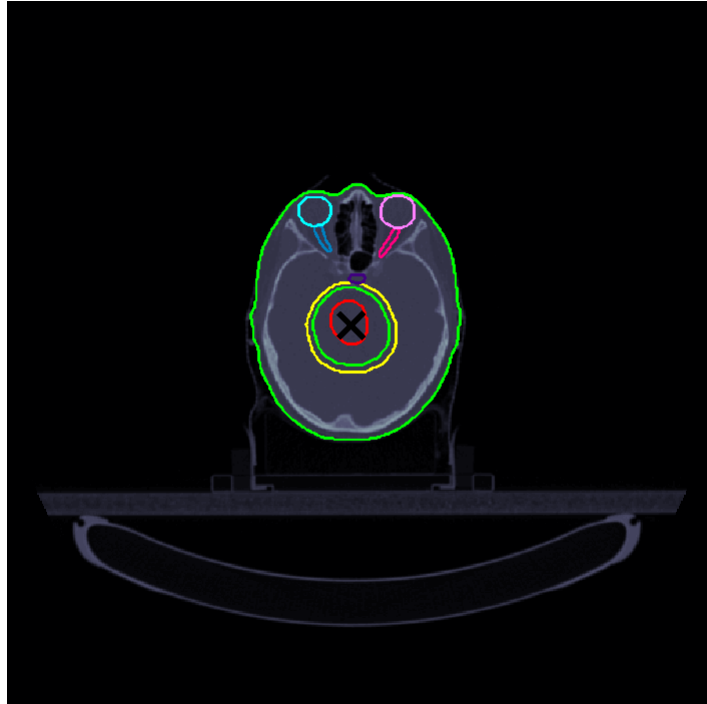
Axial view of the CT at the isocenter with delineated organs at risk and targets, GTV in red, CTV in green, PTV in yellow, left and right eye in pink and blue respectively, left and right optical nerves in dark pink and dark blue respectively and pituitary gland in purple.
